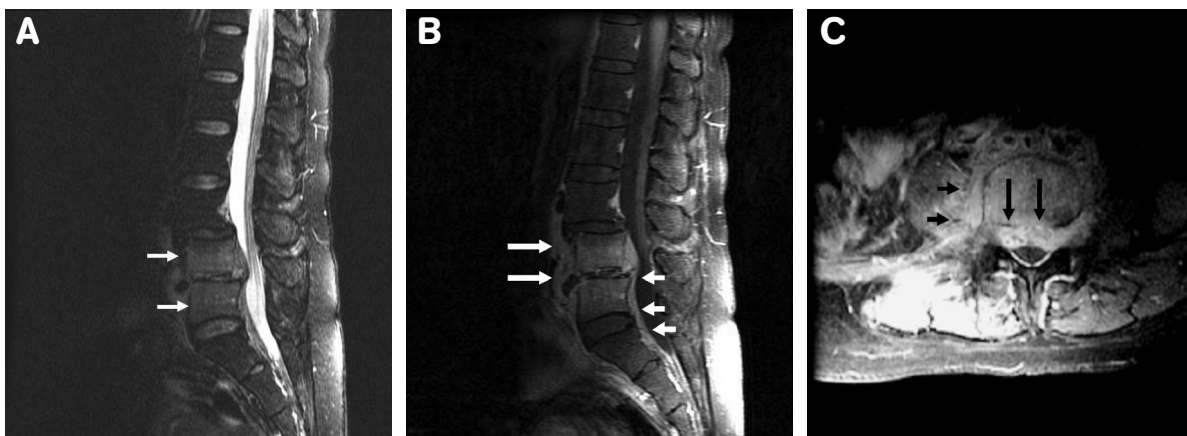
Magnetic resonance imaging findings of the spinal epidural abscess caused by *Staphylococcus aureus* infection in a 48-year-old woman. Figure 1A (T2-weighted fat-suppression imaging) shows a hyperintense marrow-density change (arrows) at L4 and L5 vertebral bodies. Figure 1B [gadolinium diethylenetriaminepentaacetic acid (DTPA)-enhanced T1-weighted fat-suppression imaging] shows homogenous enhancement at L4 and L5 vertebral bodies, anterior epidural space (short arrows), and prevertebral soft tissue (long arrows). Figure 1C (gadolinium DTPA-enhanced T1-weighted fat-suppression imaging) shows multiple abscesses with ring enhancement at the prevertebral soft tissue (short arrows) and anterior epidural abscess (long arrows).
